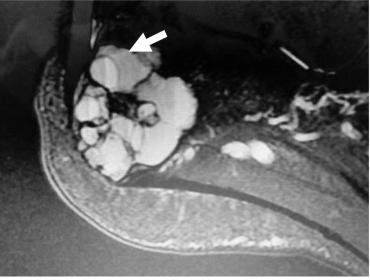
Aneurysmal bone cyst. Lateral view of the ankle (a) demonstrates a well-defined, heterogeneous, osteolytic lesion with cortical thinning (arrow). MRI STIR image (b) shows fluid–fluid levels (arrow) as well as the presence of a solid component consistent with secondary aneurysmal bone cyst, superimposed on chondroblastoma.
